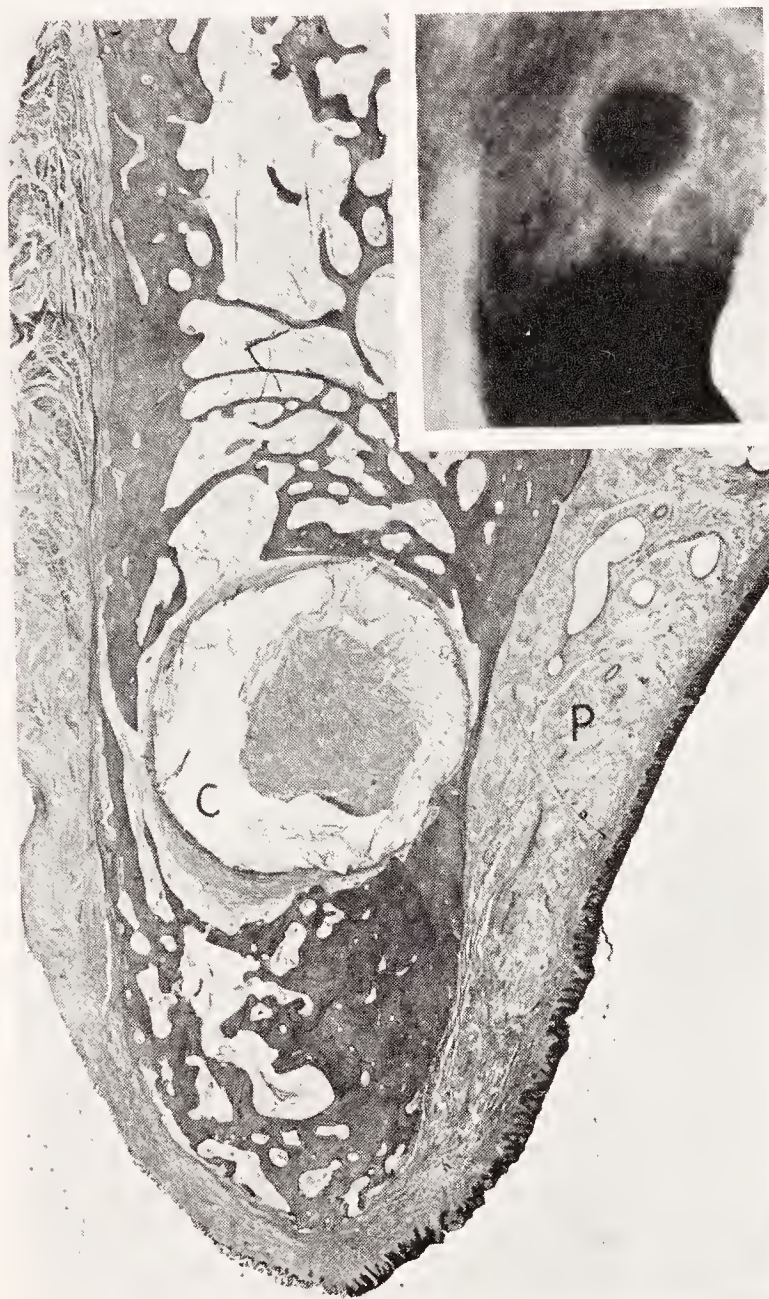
Small radicular cyst that remained in the jaw after loss of the teeth. The radiograph shows a distinct, round bone defect in an edentulous area. The corresponding tissue section reveals a radicular cyst without inflammatory tissue reaction either in the cyst or in its vicinity. Edentulous area of upper cuspid and first bicuspid; aged fifty-six years. *C*, cyst containing cholesterol; *P*, palatine tissue. (Kronfeld, Australian Dental Congress.)
